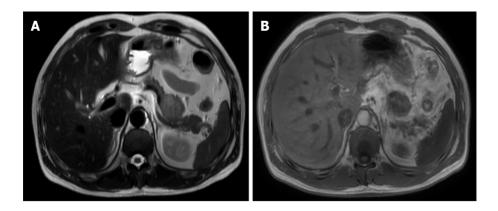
Magnetic resonance imaging showed an abnormal blocky signal found in the pancreato-gastric space, with a size of about 3.1 cm × 2.9 cm × 2.7 cm. The boundary between the local lesion and the pancreatic body was not clear. A: T1W1 showed equal and slightly lower signal; B: T2W1 showed a slightly higher signal. The enhanced scan showed progressive uneven enhancement.
